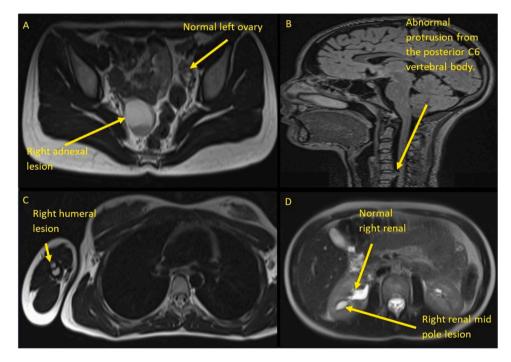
Incidental findings on MRI. A) T2 weighted MRI, axial section. Demonstrates 3.7 cm predominantly high T2 signal cystic structure in the right adnexa with lower signal material layered posteriorly within this, creating a fluid-fluid level. Right ovary not seen separately. Felt most likely to be a haemorrhagic right ovarian cyst. B) T2 fluid attenuated MRI, sagittal section. Performed as part of the initial screening MRI head. Demonstrates posterior protrusion at C5/6 felt to represent a disc osteophyte bar with indentation of the ventral cord. C) T2 weighted MRI, axial section. Demonstrates a well-defined T2 hyperintensive focus centred upon and expanding the cortex of the right humeral metaphysis over multiple axial sections. D) T2 weighted MRI, axial section. Demonstrates 18 mm right renal mid pole lesion of homogenous T2 hyperintensity. No evidence of diffusion restriction. Most in keeping with a small renal cyst.
